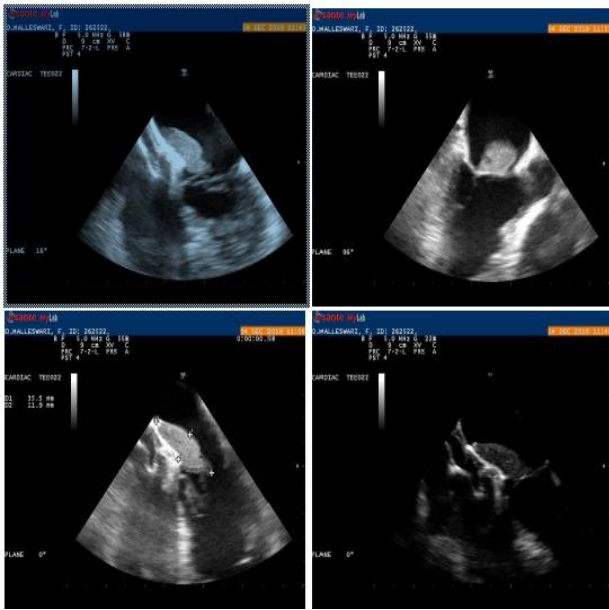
Transesophageal echocardiographic images showing the location and extent of thrombus attached to atrial septal defect closure device (Upper left-A) Four chamber view of thrombus on the ASD device, Upper right- B) Three chamber view of thrombus protruding into left ventricle inflow, Lower left- C) Four chamber view of thrombus dimensions and Lower right- D) Four chamber view of thrombus encroaching the AML
